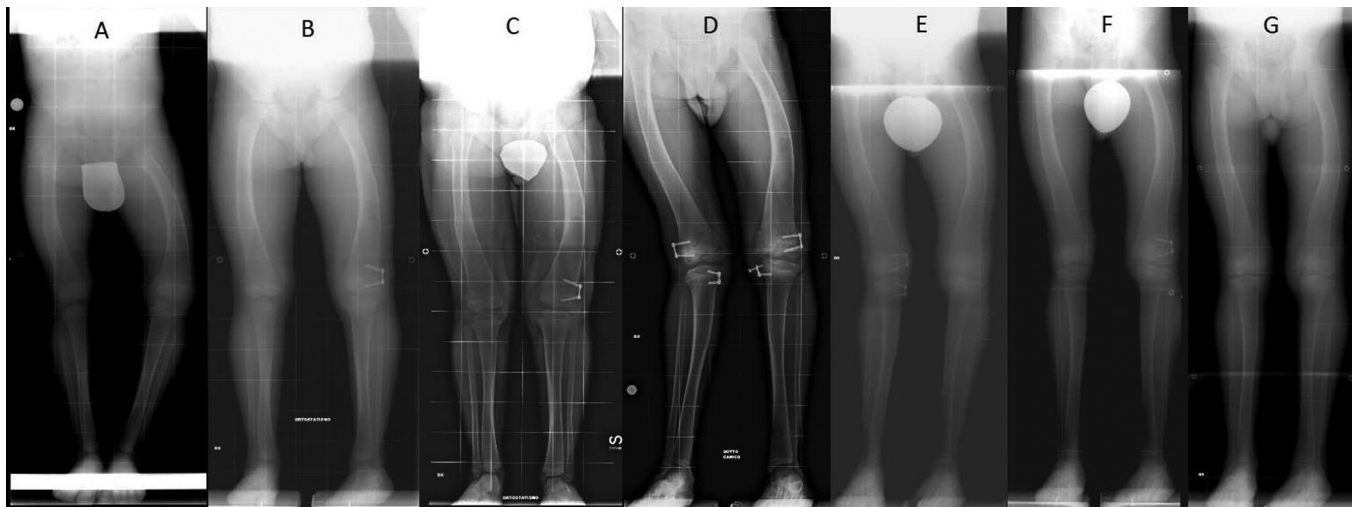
Patient radiograph evaluation: (a) at eight years of age; (b-f) periodic follow-up of the patient with development of windswept deformity and subsequently correction by guided growth technique; (g) at final follow-up at 16 years of age.
